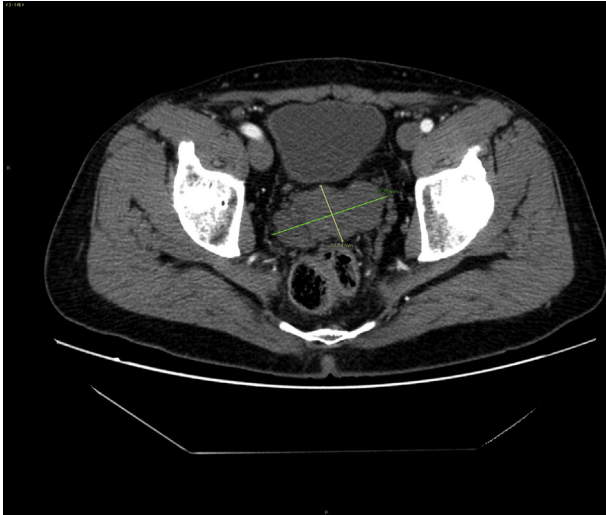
Axial CT of the pelvis demonstrated a large lobulated multiloculated cystic lesion of left seminal vesicle; after injection of intravenous contrast material, the cystic lesion did not show enhancement.
